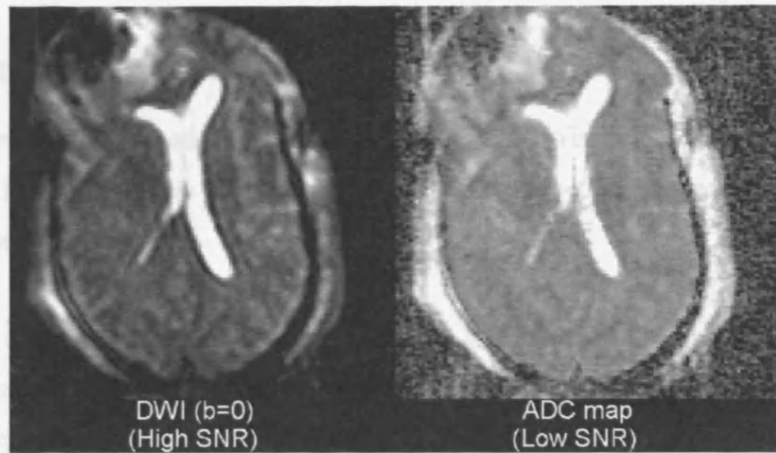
Image signal to noise ratio. The $b=0$ DWI image has the same structure as the ADC map but the high SNR makes it preferable for coregistration.
